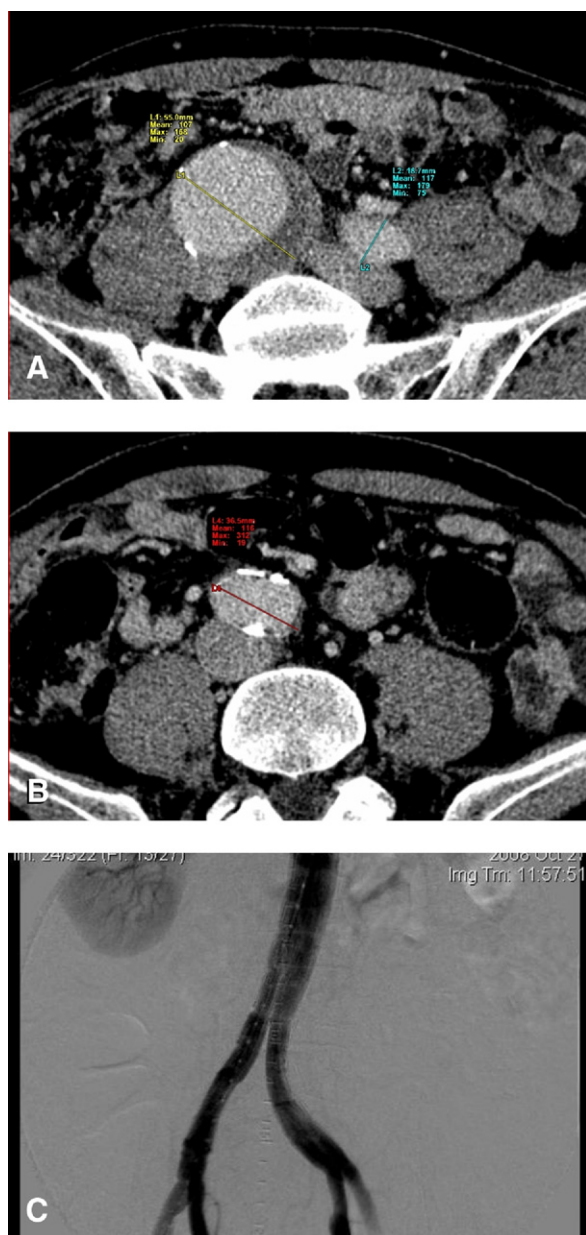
Computed tomography (CT) scan before the original endovascular aneurysm repair (EVAR) with iliac branched, showing the large iliac aneurysm (A), the dilated aorta (B) and the completion angiography after endograft placement (C).
